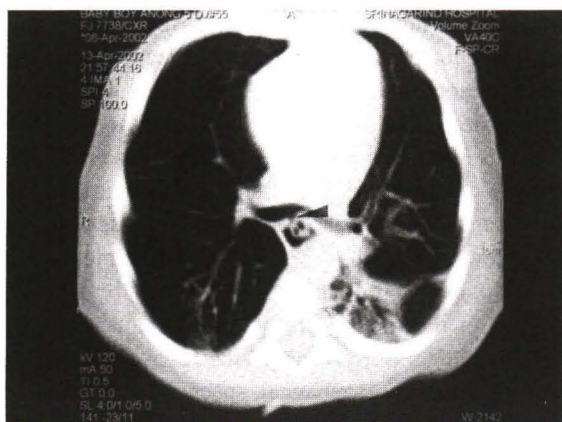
Chest CT scan reveals a small fistula (arrow) between posterior aspect of the right proximal bronchus and the esophagus.
